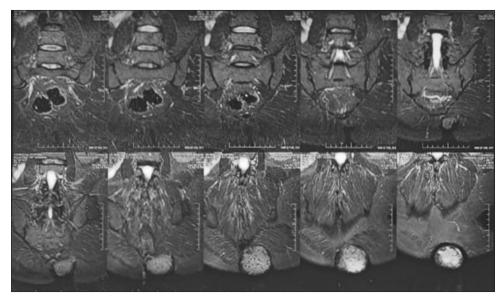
Contrast magnetic resonance imaging of LS spine
